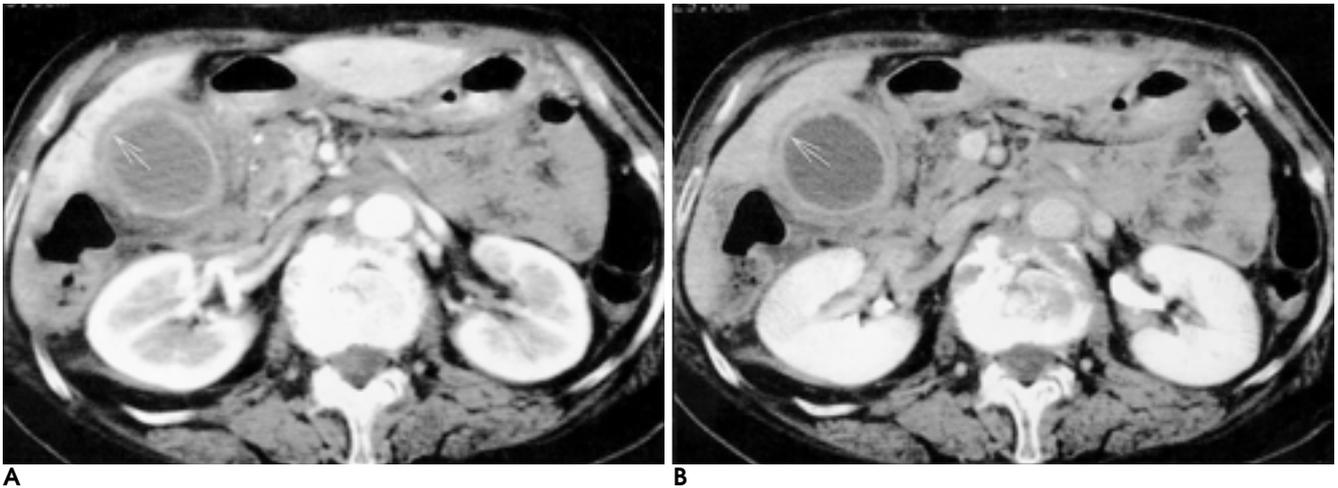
Acute cholecystitis. Two phase spiral CT scan shows iso-attenuated thin inner wall layer (arrow) on both the arterial (A) and venous phase (B) scans.
